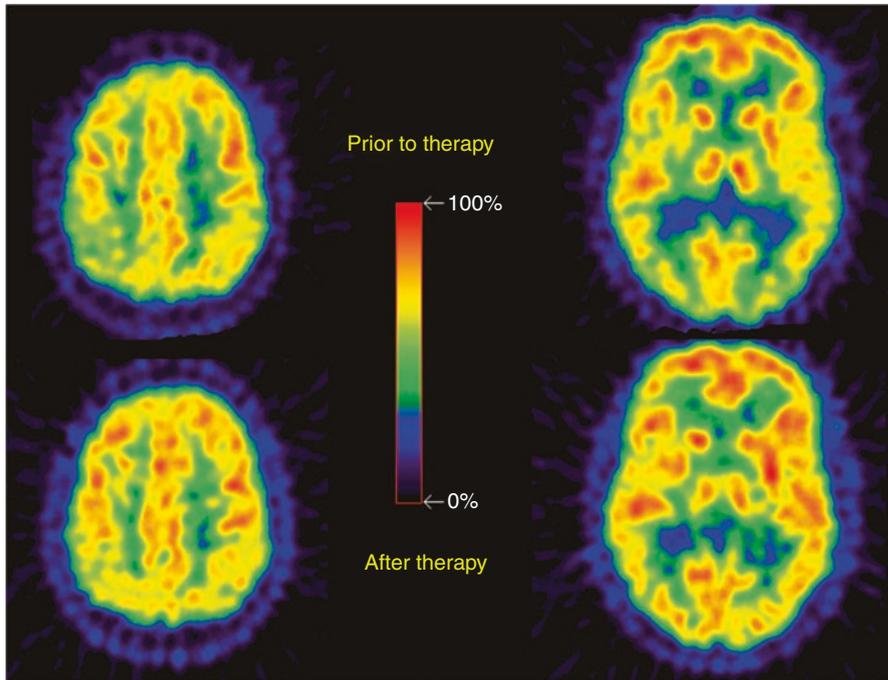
Systemic lupus erythematosus. FDG-PET prior to (*upper row*) and after immunosuppressive therapy (*lower row*). Prior to the treatment, hypometabolism in the right parietal region and both posterior parietal occipital regions can be seen. After therapy, all regions have normal metabolism. Right image side = left brain side and vice versa. (This figure has been published in Otte et al. (1998d), by SAGE Publications Ltd., all rights reserved, ©SAGE)
